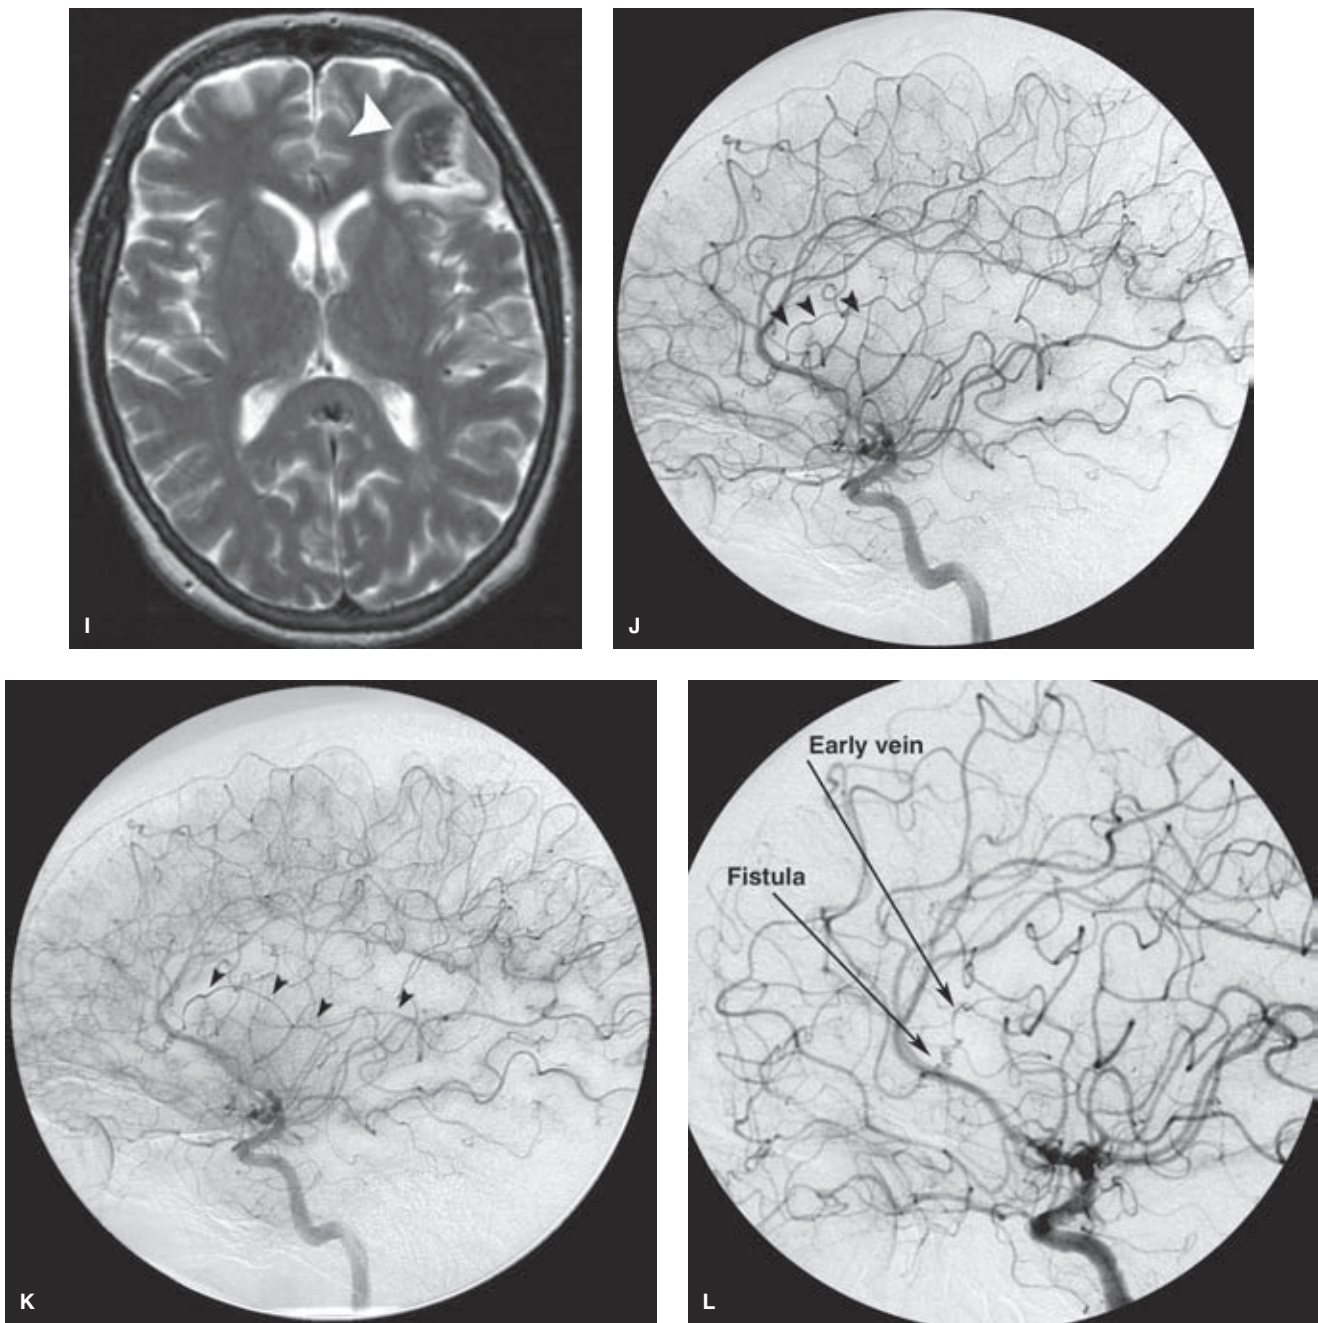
(CONTINUED) Case 3. I–L: A 45-year-old female presented with a left frontal hemorrhage (*arrowhead* in I, T2-weighted MRI). At first glance, the angiogram of the left internal carotid artery shows no major abnormality, but a more careful review of the lateral angiogram (arterial phase J, early parenchymal phase K) reveals that an abnormal vessel (*arrowheads*) appears early and courses posteriorly to join the left transverse sinus. This is an early draining vein, and one must always be on the qui vive for subtle findings of this nature because they can imply as much risk to the patient as do the florid findings shown in Figure 19-9. Magnification oblique view (L) demonstrated the microfistula more clearly. (*continued*)
